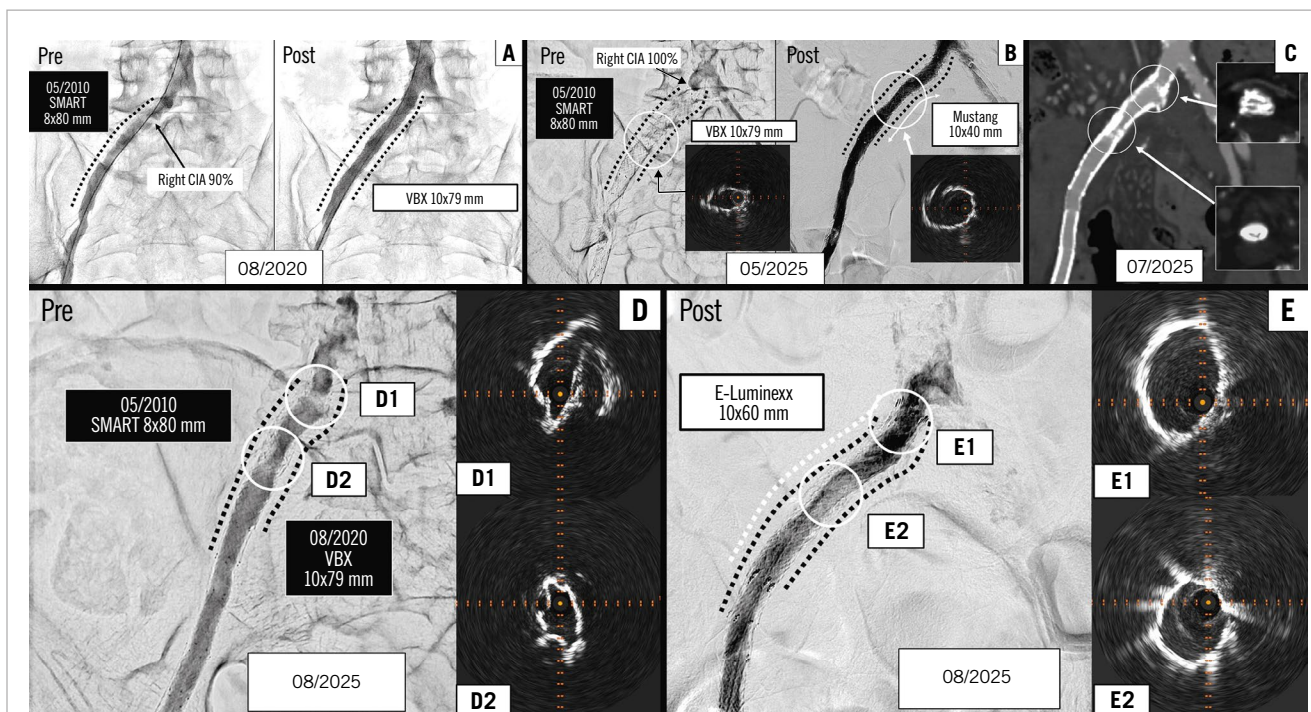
Serial imaging findings demonstrating progressive protruding calcification and acute iliac stent occlusion. Under angiography, a 90% stenosis was identified in the right common iliac artery (CIA), and a balloon-expandable covered stent was deployed (A). At the onset of acute limb ischaemia, intravascular ultrasound (IVUS) revealed an underexpanded area of the stent, which was subsequently dilated using a 10 mm Mustang (Boston Scientific) balloon catheter (B). Contrast-enhanced computed tomography demonstrated in-stent restenosis of the common iliac artery secondary to extrinsic compression by calcified tissue (C). During reintervention, IVUS revealed significant luminal narrowing resulting from external calcified compression (D). Following implantation of a self-expanding stent, IVUS confirmed sufficient luminal expansion and restoration of vessel patency (E).
